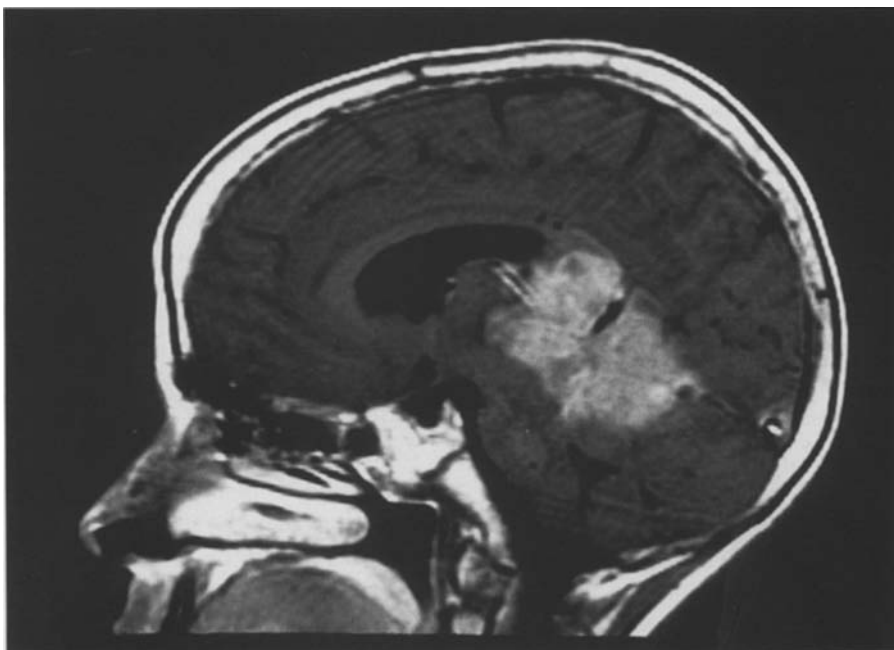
(a and b). Sagittal and coronal gadolinium enhanced MRI scans of a 12 year old boy who presented with Parinaud's syndrome and signs and symptoms of raised intracranial pressure. The MRI scan shows a massive, uniformly enhancing lesion in the pineal region. He underwent a subtotal (80%) resection of a PNET. Interestingly, he presented with a similar tumor 8 years previously and was treated with a ventriculoperitoneal shunt and craniospinal radiation without a tissue diagnosis. His tumor was observed to completely disappear on follow up examination. Following surgery of recurrence he was treated with chemotherapy, but, his tumor progressed and he died after a further 18 months.
